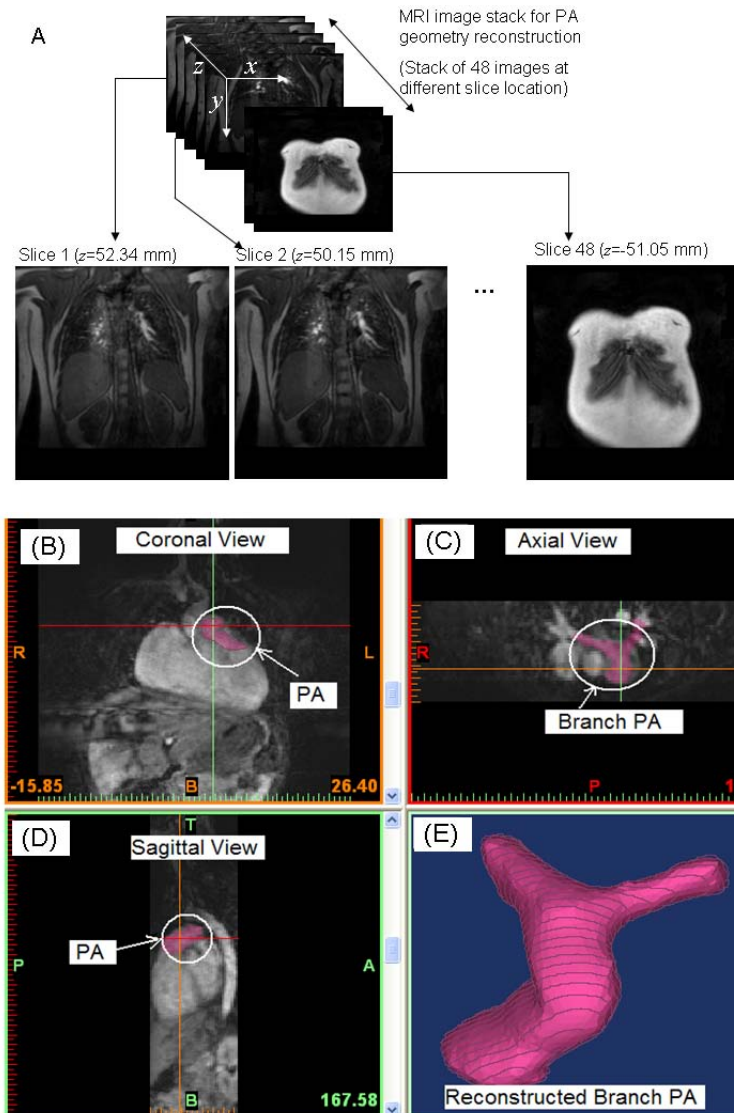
Geometry reconstruction from the patient specific MRI images: (A) Stack of 3D MRI images of subject's chest used for PA geometry reconstruction; (B), (C), (D) representing the coronal, axial and sagittal views respectively with PA identified by assigning masked by specifying grey scale value from the image. (E) The reconstructed branch PA geometry without the inlet and outlet cine-phase contrast velocity measurement planes. This geometry is exported as a file of STL triangles to create blood flow domain with inlet outlet surfaces which get defined by the velocity measurement planes.
